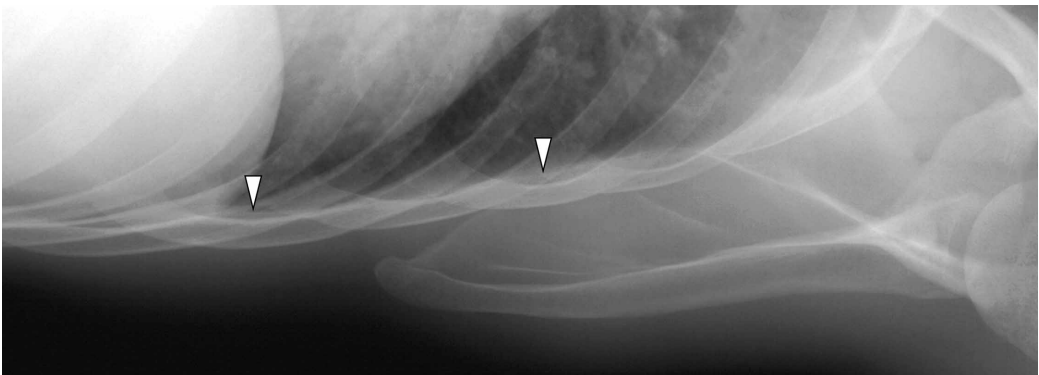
Left lateral decubitus expiratory radiograph showing 3 mm thick density with horizontal level (arrowhead over phrenicocostal sinus), consisting with criterion defining pleural fluid. Medial margin of the scapula should not be misinterpreted as pleural fluid accumulation (arrowhead at the level of 4th rib).
